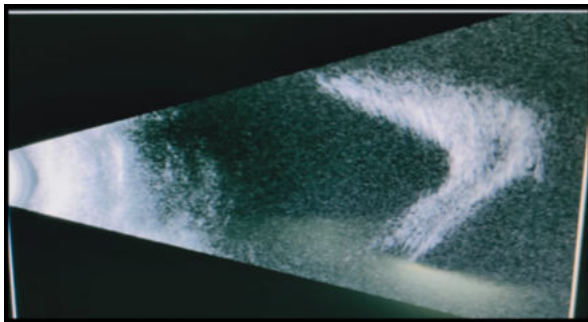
Ultrasonography Of The Globe Shows Retinal Detachment.
